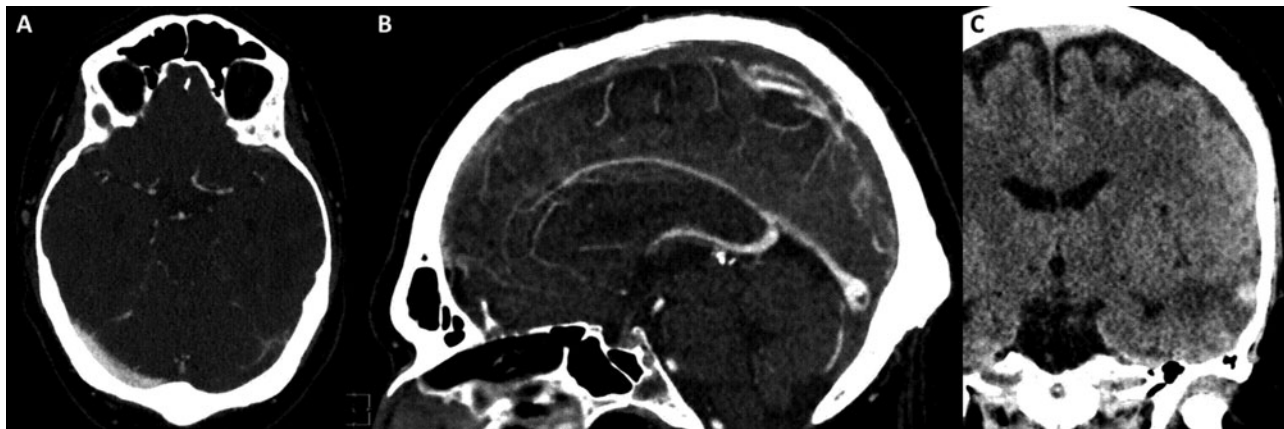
Cerebral venous sinus thrombosis with haemorrhagic infarct associated with COVID-19. (A) CT scan of head with contrast (1 mm axial) showing left transverse sinus thrombosis. (B) CT scan of head with contrast (sagittal) showing extensive superior sagittal sinus thrombosis. (C) CT scan of head (2 mm coronal minimum intensity projection) showing haemorrhagic infarct and surrounding oedema in the left temporal lobe.
